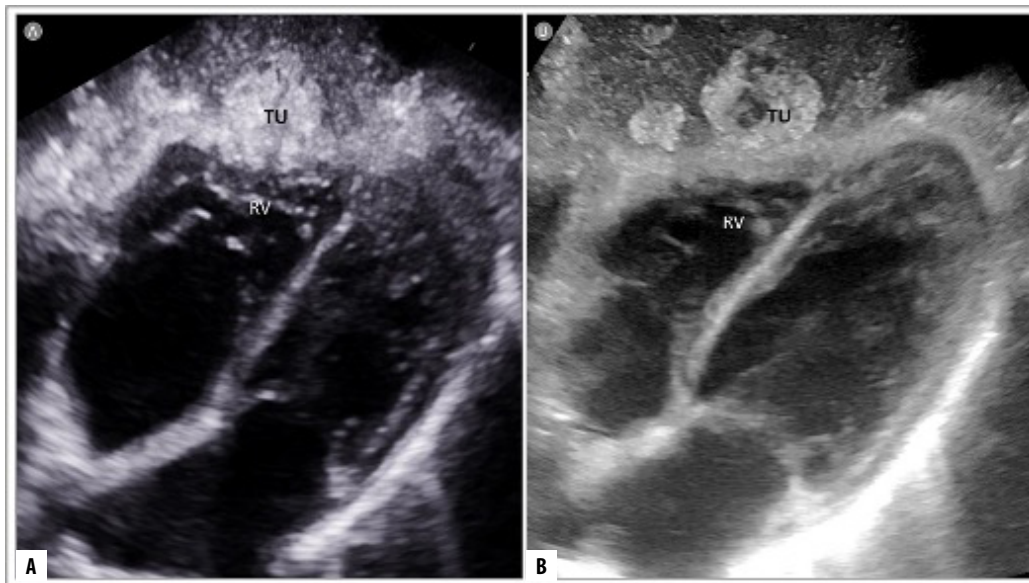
Right ventricle compression by liver metastatic tumor (Tu) - subcostal echocardiographic view using cardiac sector probe (A) and convex probe (B).
